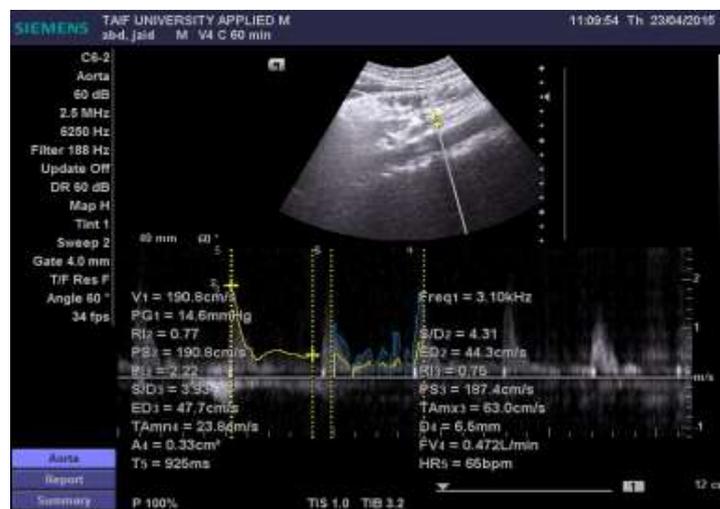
Duplex sonogram of the SMA showing peak systolic velocity with other parameter
